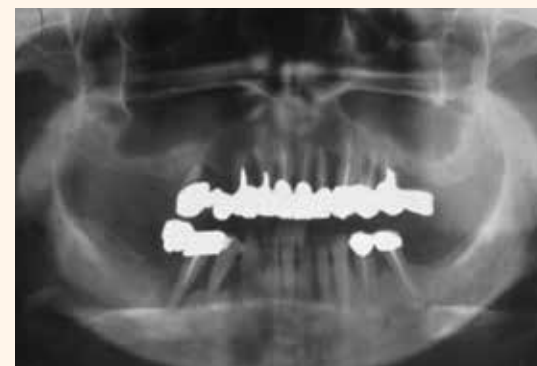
Preoperative panoramic radiograph of 50-year-old caucasian woman
